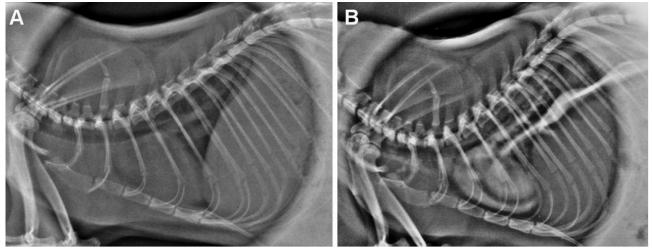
Plain (A) and contrast (B) radiographic studies of the thorax in the left lateral recumbency (parameters: 65 kVp, 8 mA, 0.1 s, 30-cm film-focus distance).
